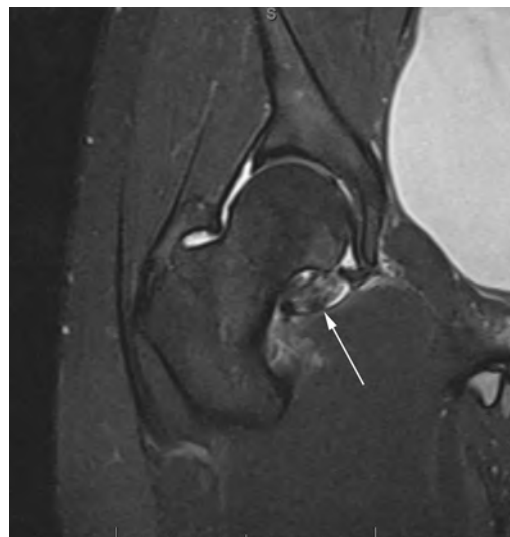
Coronal magnetic resonance imaging (T1-weighted) of the patient's right hip demonstrating the hypointense lesion caused by the hemosiderin deposition in the hyperplastic synovium characteristic of pigmented villonodular synovitis (white arrow).
